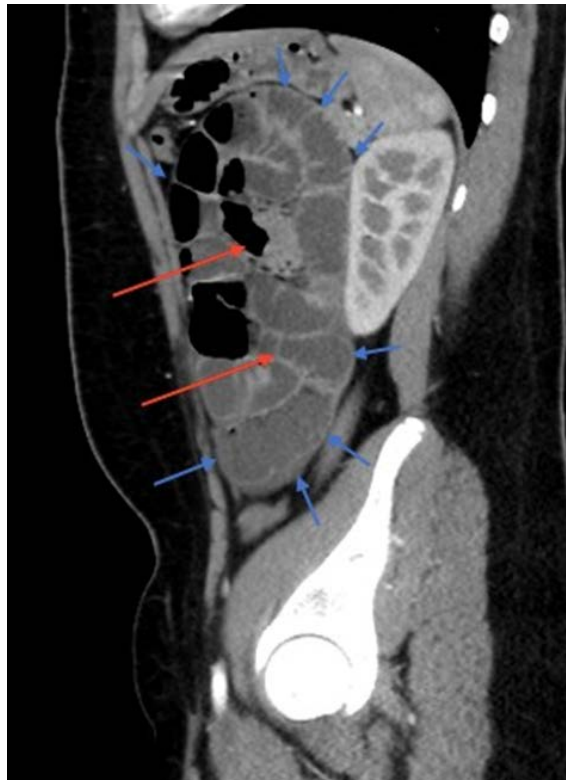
Sagittal reformatted contrast enhanced CT of the abdomen showing thin peritoneal membrane (blue arrow) encapsulating clusters of dilated small bowel loops (red arrow) in the left abdominal quadrants.
